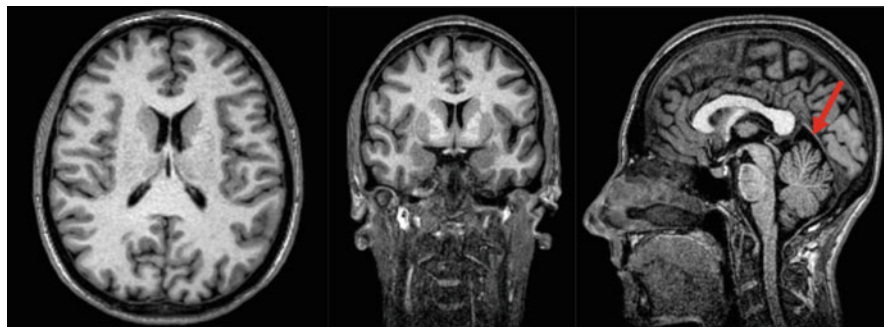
T1-weighted cross, coronal, and sagittal images, showing a normal amplitude of the ventricular system and of the peripheral liquor spaces, except for a minimal extension of the design of the cerebellar folia (red arrow)
